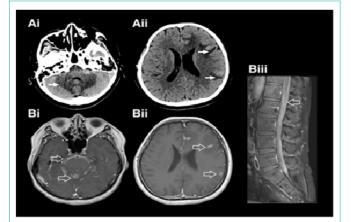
A: Computed Tomography (CT) head (axial) demonstrating vasogenic edema (filled arrows) in the cerebellum (i) and cortex (ii). B: Magnetic resonance imaging with gadolinium (axial) demonstrating diffuse leptomeningeal enhancement (open arrows) in the posterior fossa (i) cortex (ii) and sagital lumbar spine (iii).
